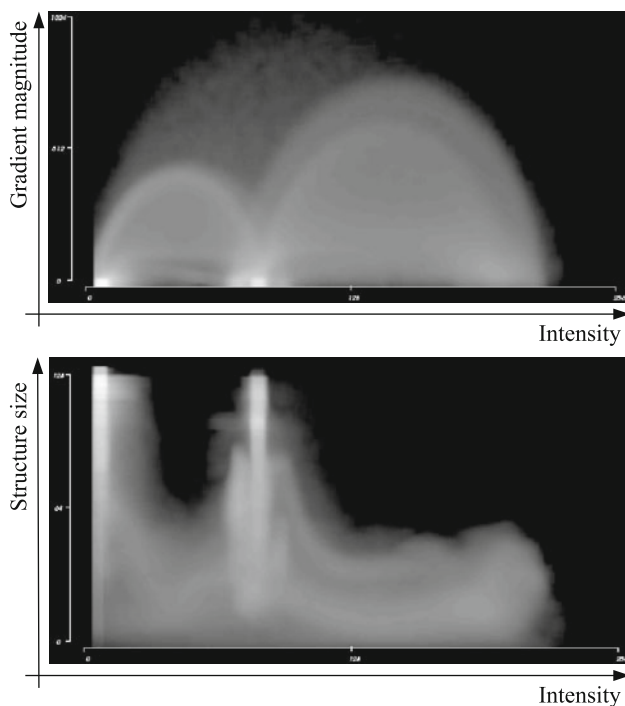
A conventional IGM histogram (*top*) compared to the new SSE histogram (*bottom*), both computed for a head CT image data set (see Figs. 3, 6). The brightness of the 2D bins corresponds to the bin frequency. The IGM histogram shows the typical arch structures representing boundaries in the image data (see [10])
